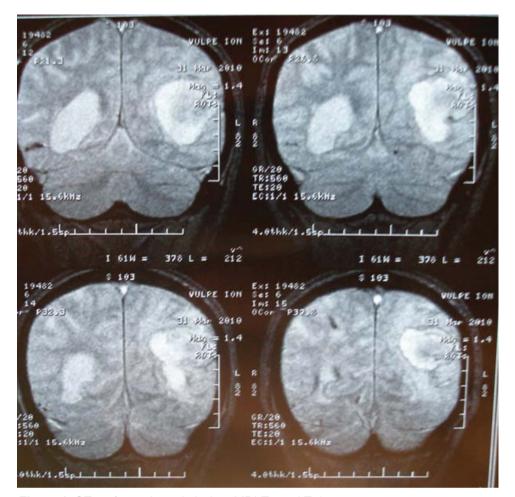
CT performed at admission, MRI-T2 and T2*
